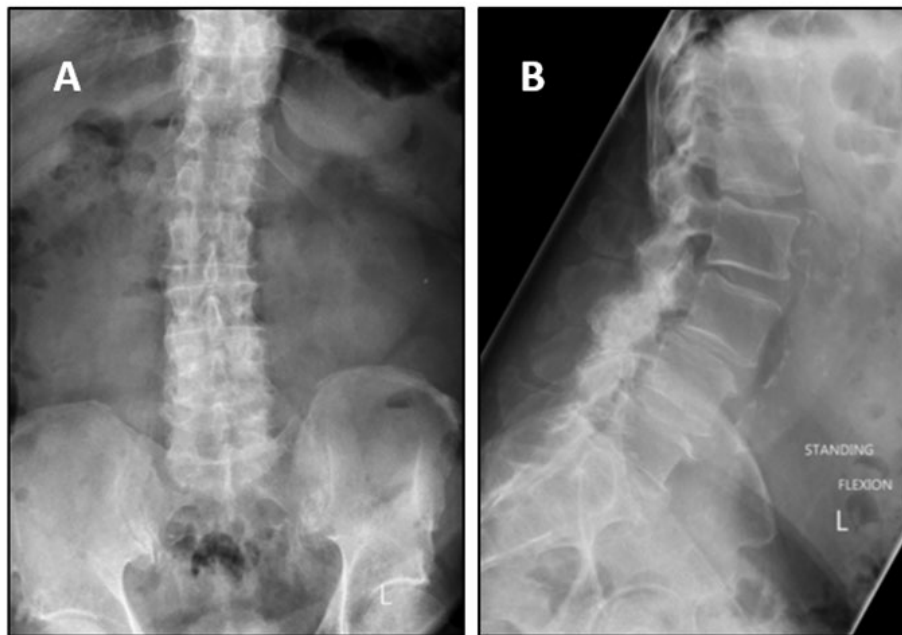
Preoperative A/P (A) and lateral (B) plain radiographic images of the lumbar spine. patient is 75 and had surgery for degenerative lumbar stenosis and Grade 1 spondylolisthesis at L3 – L4
